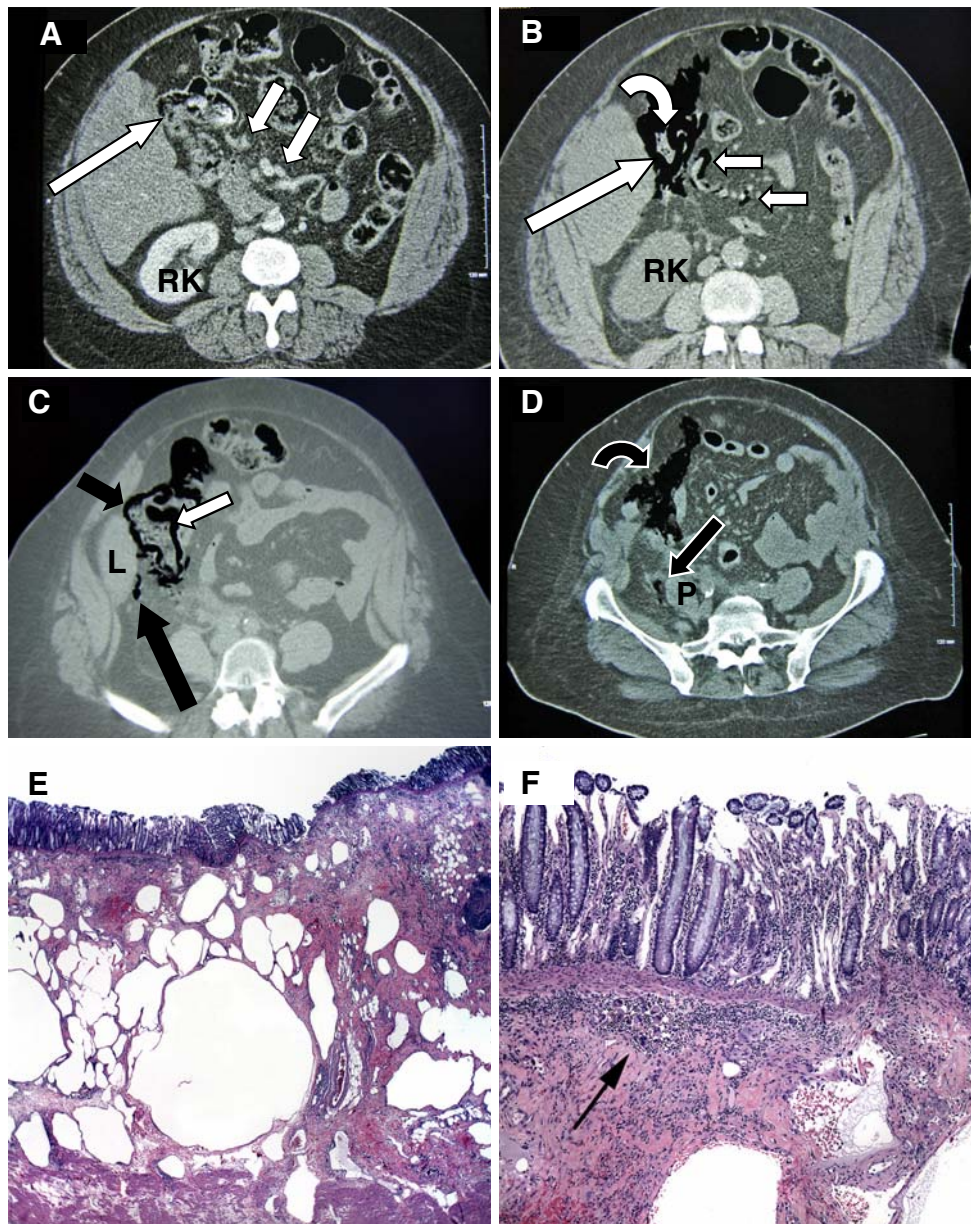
(Patient 1) a CT scan, with oral and IV contrast, 1 month before presentation with pneumatosis. Axial image, shows normal collapsed hepatic flexure (*long arrow*) containing intraluminal feces admixed with gas and contrast. No pneumatosis is demonstrated and there is no gas tracking along the mesenteric vasculature (*short arrows*). Note right kidney (*RK*). b Noncontrast CT shows gas in the wall of the hepatic flexure (*long arrow*) surrounding intraluminal material (*curved arrow*). Gas also tracks along the superior mesenteric artery and vein branches (*short arrows*). Note right kidney (*RK*) and absence of the left kidney following nephrectomy. c At an axial level that includes the liver tip (*L*), high-contrast electronic windowing better demonstrates gas in the wall of the hepatic flexure (*short black*
